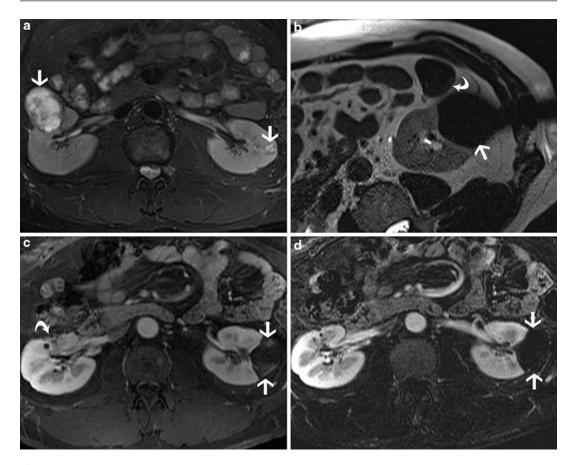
A 51-year-old man with a history of lymphoma. Axial, fat-suppressed, T2-weighted MRI (a) shows bilateral renal masses (*arrows*). The patient underwent right partial nephrectomy and pathology revealed renal cell carcinoma. 3 T MRI-guided cryoablation performed since the lesion was better seen with MRI. Axial, T2-weighted MR image (b) obtained during procedure shows signal void area of the iceball
